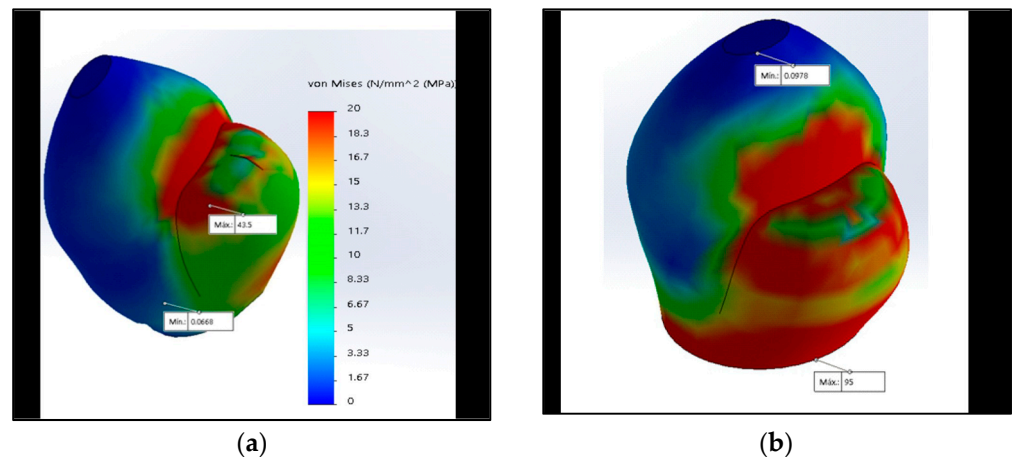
The maximum stress with 350 N at the crown is represented by red using the von Mises scale: (a) Maximum stress in the occlusal face in the CT connection; (b) maximum stress in the neck in the MT connection.
